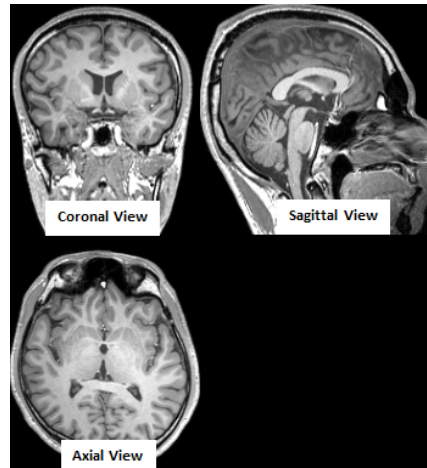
Sample of T1-weighted sMRI scan (Dark, light, gray, and bright colors denote cerebrospinal fluid, white matter, cortex, and fat, respectively.).
